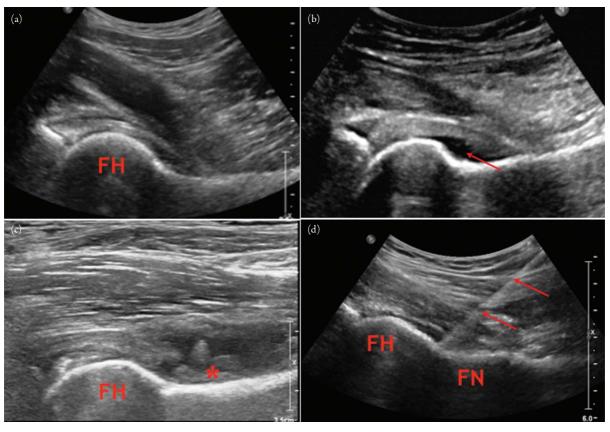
Anterior hip ultrasound. Panel (a) shows a grayscale sonographic image of the anterior hip joint recess in a patient without a hip joint effusion. In Panel (b) there is a small hip joint effusion, which appears as a region of anechoic fluid (arrow) anterior to the linear echogenic femoral cortex. Another patient with a small-moderate volume, complex hip joint effusion (Panel (c)) containing irregular echogenic debris (*) suggestive of synovitis. Panel (d) shows the tip of a 22-gauge spinal needle positioned at the femoral head-neck junction. This is the target site for the needle tip when performing diagnostic hip joint aspirations or therapeutic injections. All above images are grayscale ultrasound images of the anterior hip in the longitudinal plane.
